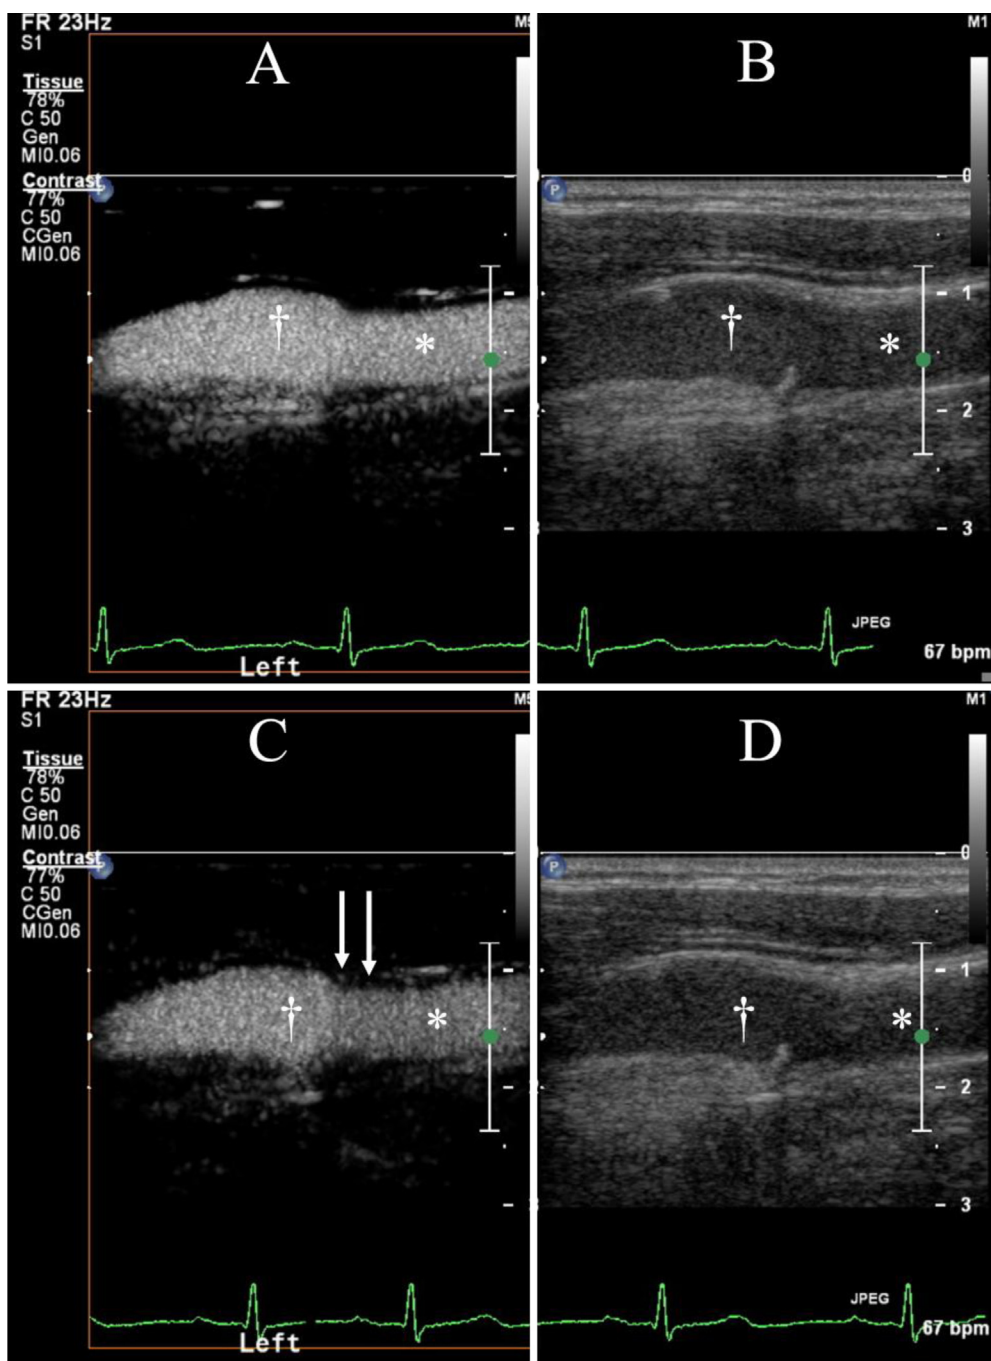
Example of side-by-side contrast enhanced ultrasound (CEUS) examination. *common carotid artery, †carotid bulb. Panel A: CEUS clip of the left carotid artery shortly after contrast injection. Panel B: corresponding B-mode clip of the left carotid artery recorded simultaneously with the CEUS clip. Panel C: A CEUS clip of the same carotid artery recorded a few seconds following contrast administration. The arrows indicate contrast-enhancement in a small atherosclerotic plaque in the carotid bulb. Panel D: corresponding B-mode clip of the left carotid artery recorded simultaneously with the CEUS clip.
